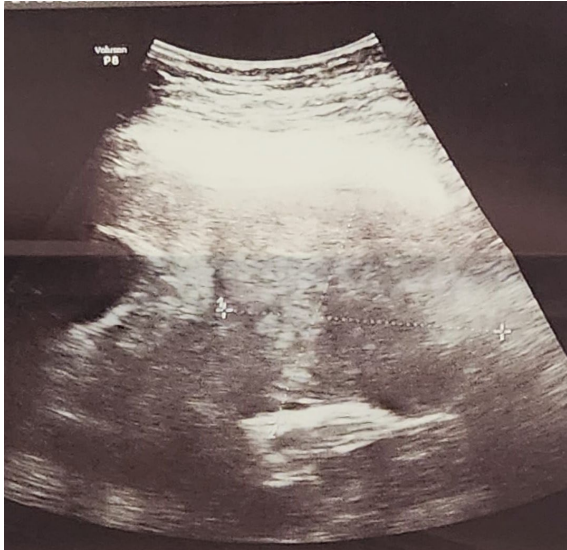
Ultrasound of the myoma with necrotic zones.
